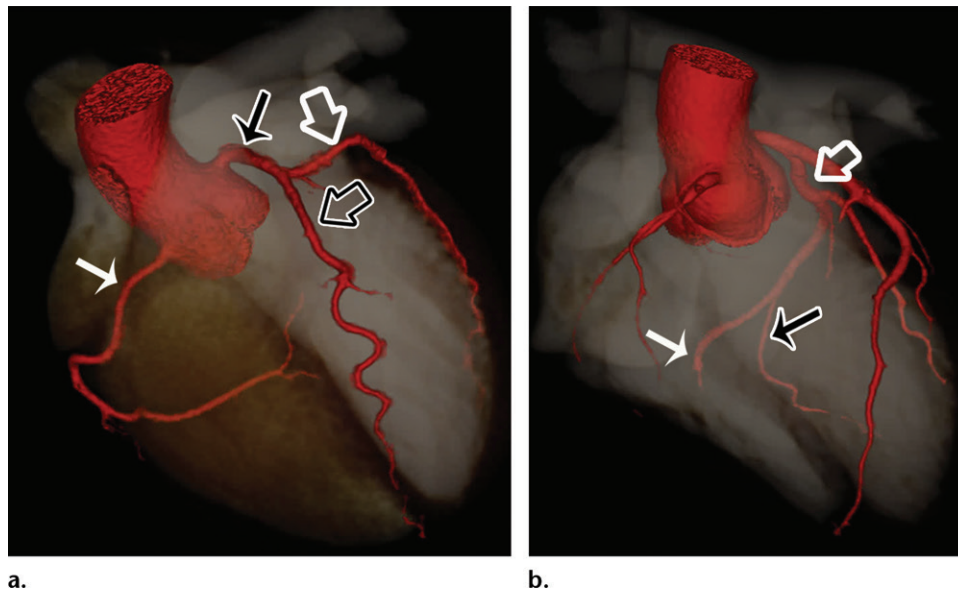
(a) Three-dimensional (3D) volume-rendered image from coronary CT angiography in a 17-year-old adolescent girl with right-dominant anatomy. The left main coronary artery (solid black arrow) arises from the left sinus of Valsalva and divides into the left anterior descending artery (LAD) (open black arrow) and left circumflex artery (LCx) (open white arrow). Diagonal branches arise from the LAD, supplying the anterior and anteroseptal myocardium, apex, and anterior two-thirds of the interventricular septum. Obtuse marginal branches arise from the LCx, supplying the anterolateral and inferolateral left ventricular wall (these smaller branches are not well seen on this 3D volume-rendered image). The right coronary artery (RCA) (solid white arrow) arises from the right sinus of Valsalva and courses in the interventricular groove, supplying the right ventricle. Coronary arterial dominance is defined by which coronary artery gives rise to the vessels that supply the inferior aspect of the heart. In this right-dominant heart, the RCA gives rise to the posterior descending artery and posterolateral ventricular branch (PLVB) and supplies the posterior one-third of the interventricular septum and inferior wall of the left ventricle. (b) Three-dimensional volume-rendered image from coronary CT angiography in a 19-year-old man with left-dominant anatomy. Left- or codominant anatomy occurs in 15%–20% of the population. The LCx (open white arrow) gives rise to the posterior descending artery (black arrow) and PLVB (solid white arrow), supplying the inferior wall of the left ventricle and posterior one-third of the interventricular septum. In codominant hearts, the posterior descending artery is supplied by the LCx, and the PLVB is supplied by the RCA.
